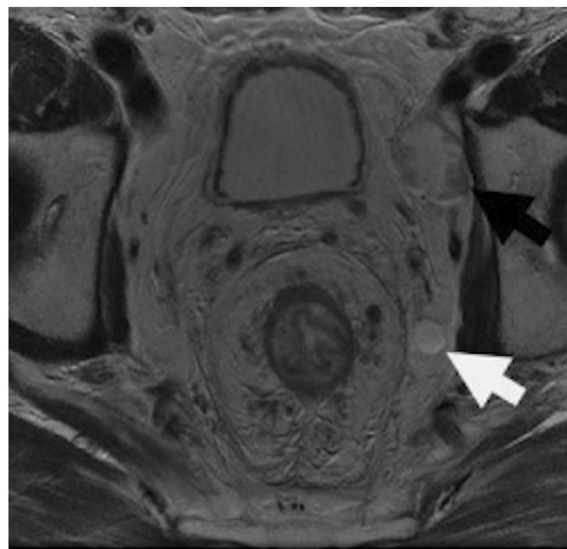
Pre-treatment staging MRI of a patient with locally advanced rectal cancer and abnormal enlarged lateral lymph nodes, with (black arrow) and without (white arrow) malignant features.
